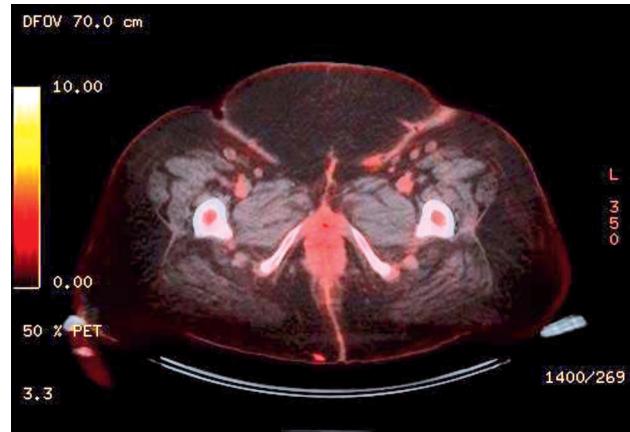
Axial PET/CT image 30 months after surgery showing no FDG uptake in area of concern on MRI in anterior vagina, suggesting MRI findings are not due to residual or recurrent disease.
